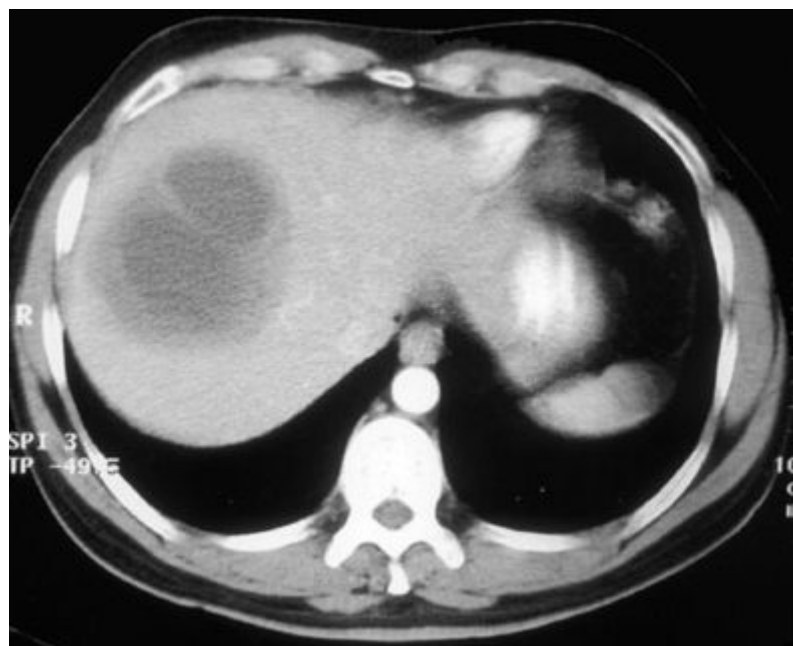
CT SCAN SHOWING LIVER ABSCESS
